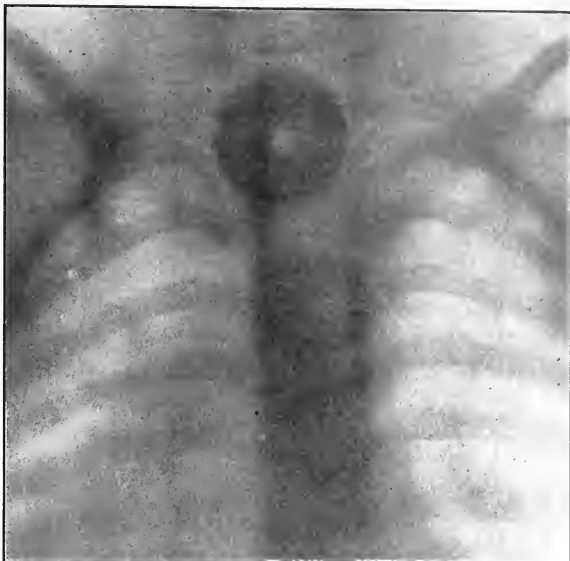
X-RAY PICTURE OF A TIN WHISTLE IMPACTED IN THE ESOPHAGUS OF A BOY AGED SIX. Under a general anesthetic I was able to extract the whistle with a coin-catcher without much difficulty.
